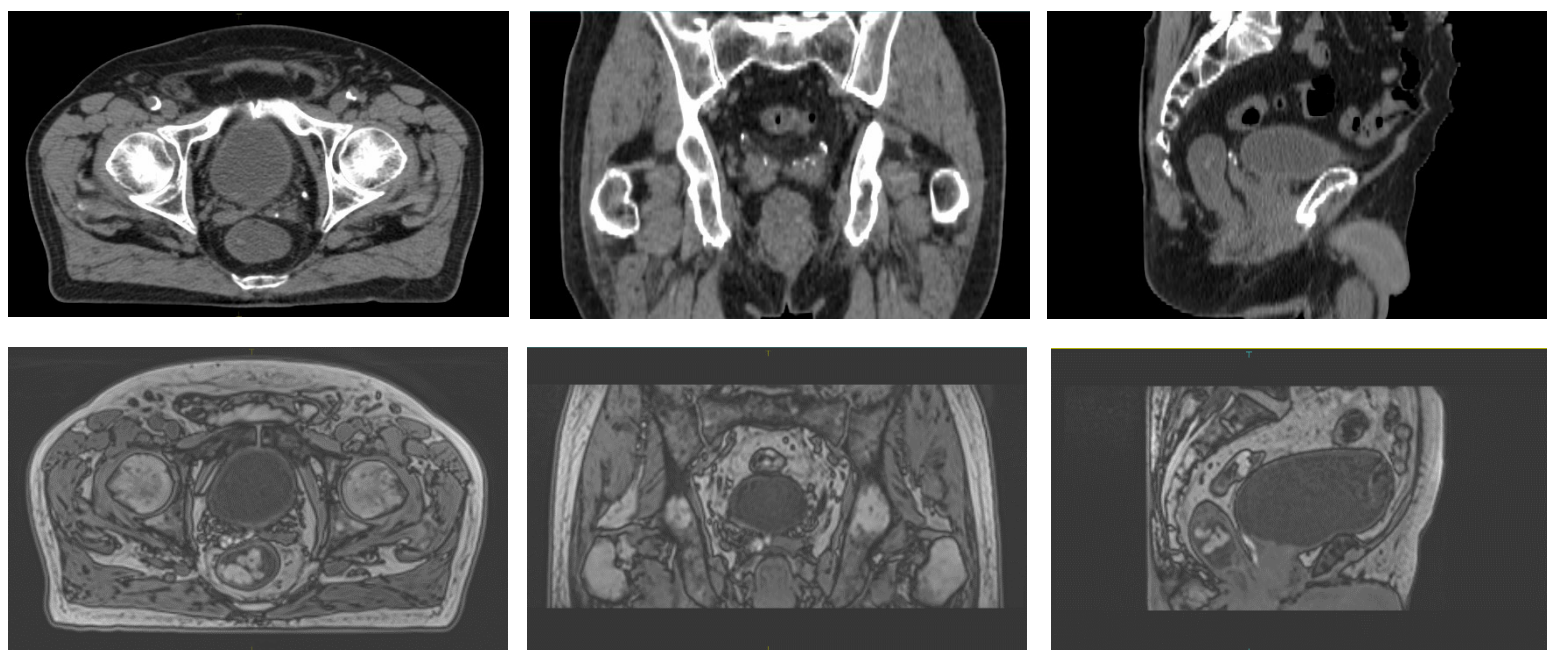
CT images (top row) vs MR ones (bottom row) used for planning purpose in our hospital.
